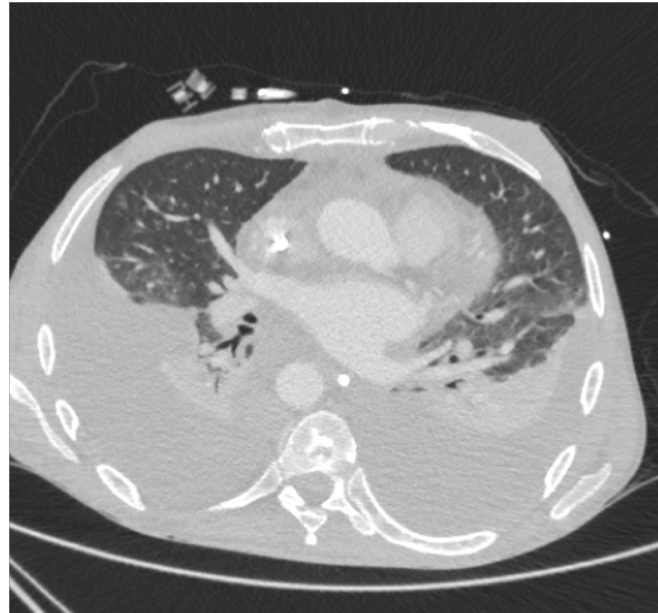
Thoracic CT scan 21 days after surgery of large bilateral pleural effusions with compressive atelectasis
